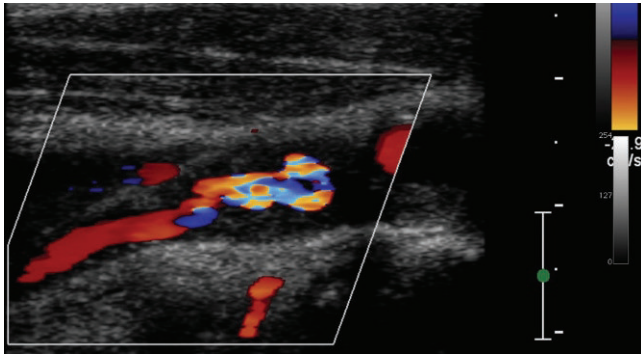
Color Doppler of the ICA stenosis shows narrowing of the color lumen. This is an approximate size of the lumen since the ultrasound is a two-dimensional representation of a three-dimensional object. In the area of narrowing proximally, the mixtures of colors is due to color aliasing from high velocity. More distally the velocity decreases and the color of the ICA flow velocity is red.
